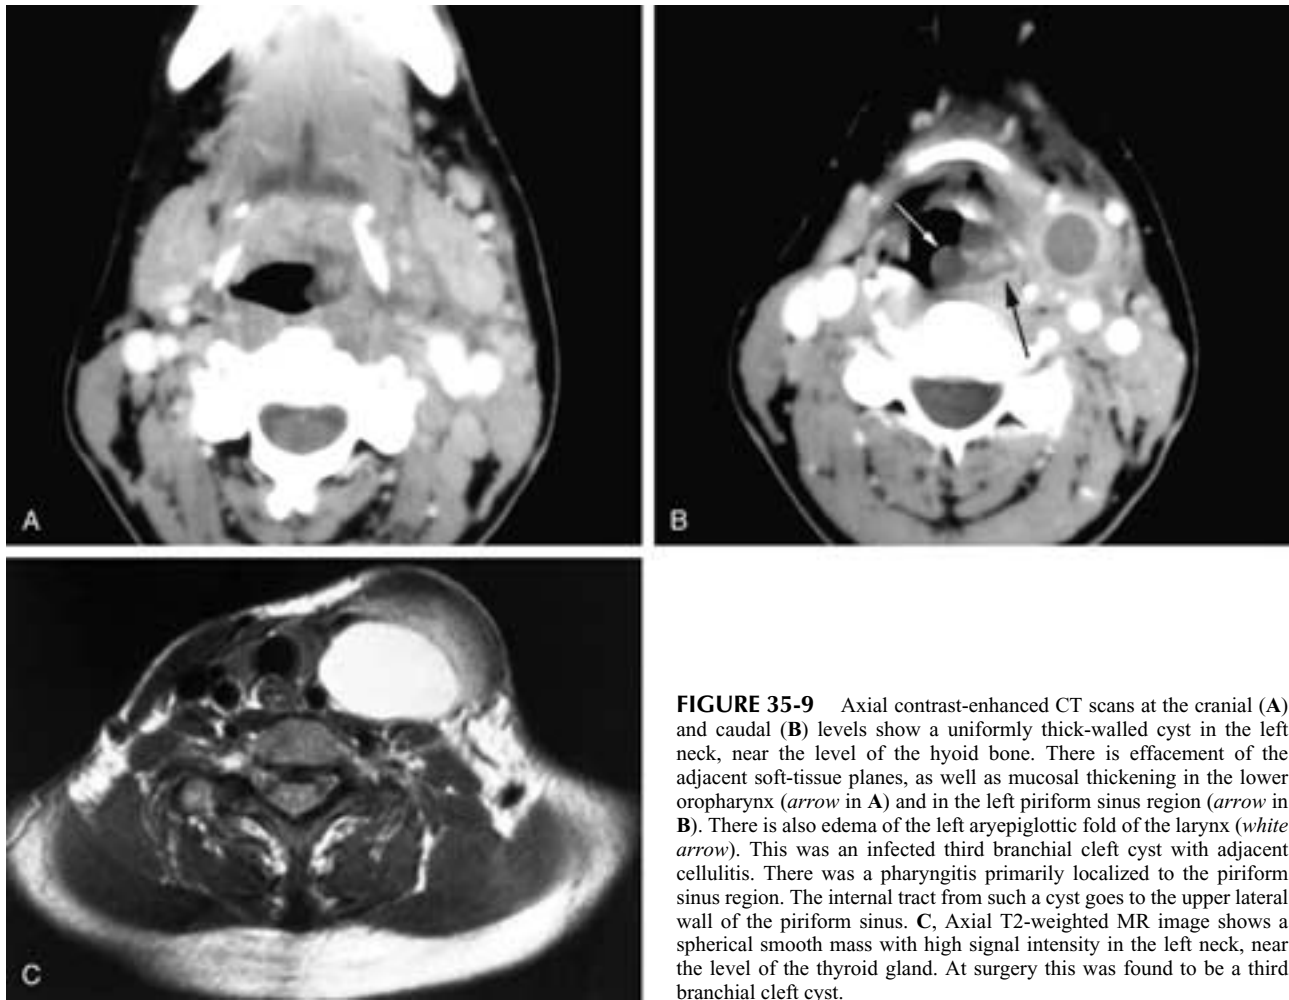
Axial contrast-enhanced CT scans at the cranial (A) and caudal (B) levels show a uniformly thick-walled cyst in the left neck, near the level of the hyoid bone. There is effacement of the adjacent soft-tissue planes, as well as mucosal thickening in the lower oropharynx (*arrow* in A) and in the left piriform sinus region (*arrow* in B). There is also edema of the left aryepiglottic fold of the larynx (*white arrow*). This was an infected third branchial cleft cyst with adjacent cellulitis. There was a pharyngitis primarily localized to the piriform sinus region. The internal tract from such a cyst goes to the upper lateral wall of the piriform sinus. C, Axial T2-weighted MR image shows a spherical smooth mass with high signal intensity in the left neck, near the level of the thyroid gland. At surgery this was found to be a third branchial cleft cyst.
